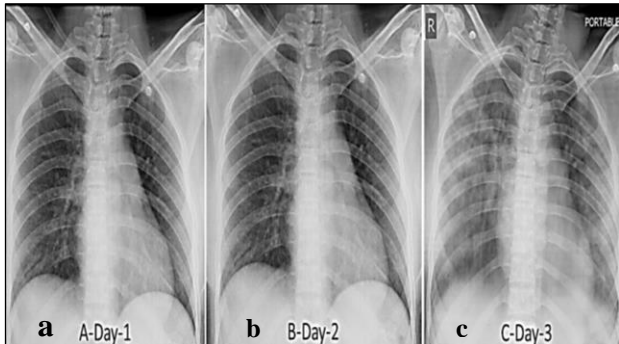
X-ray of the patient at admission (a) and within the next 48 hours (b and c).
